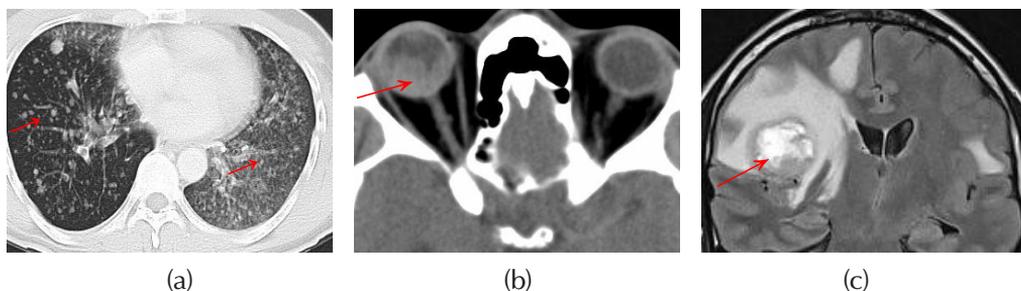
CT scans showing multiple nodules throughout lung parenchyma (a), right posterior globe thickening with retinal detachment (b), lesions of brain on MRI (c).
